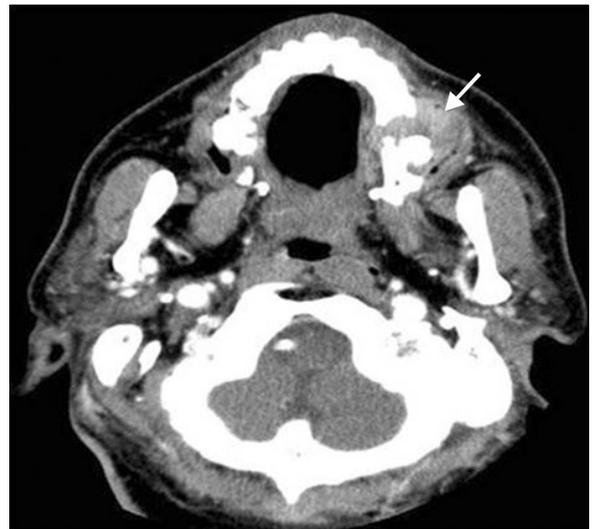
Facial CT presents malignant tumor involving the alveolar process of the left maxilla and lateral aspect of the left side hard palate (arrow).
